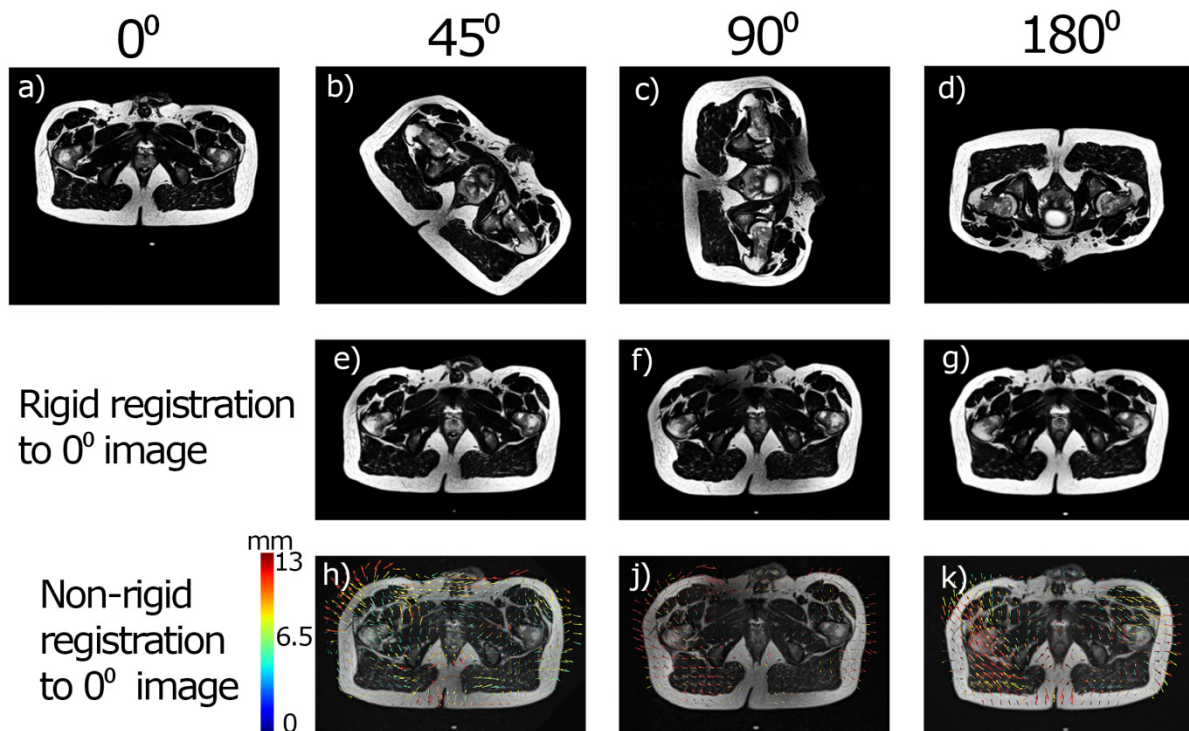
Representative MRI images. Top row shows the original images taken at a) 0, b) 45, c) 90, and d) 180 degrees. Second row shows each image after rigid contour guided registration back to the 0 degree image. Third row shows each image after non rigid registration back to the 0 degree image. The DVF from this step is overlaid on each image. (Note to reviewers: a high resolution version of this figure will be linked to from the caption)
